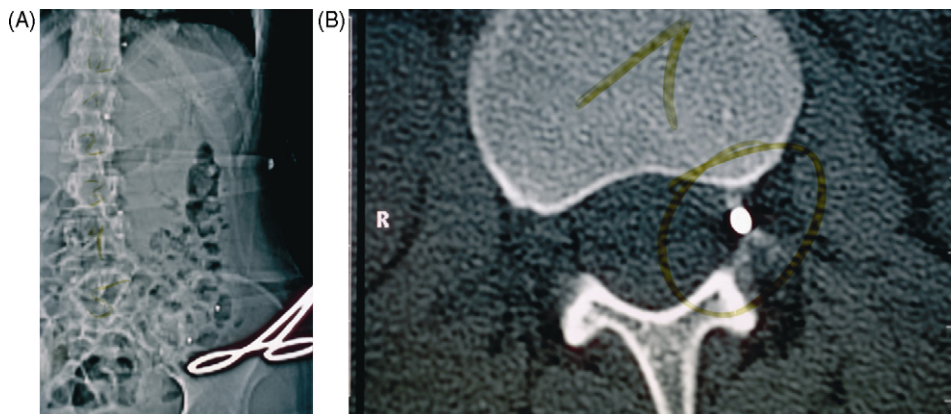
A and B: pellet (globe) near the spinal cord. Hand grenade injury, gang fighting, disco Hamburg. CT, topogram and axial cut.
